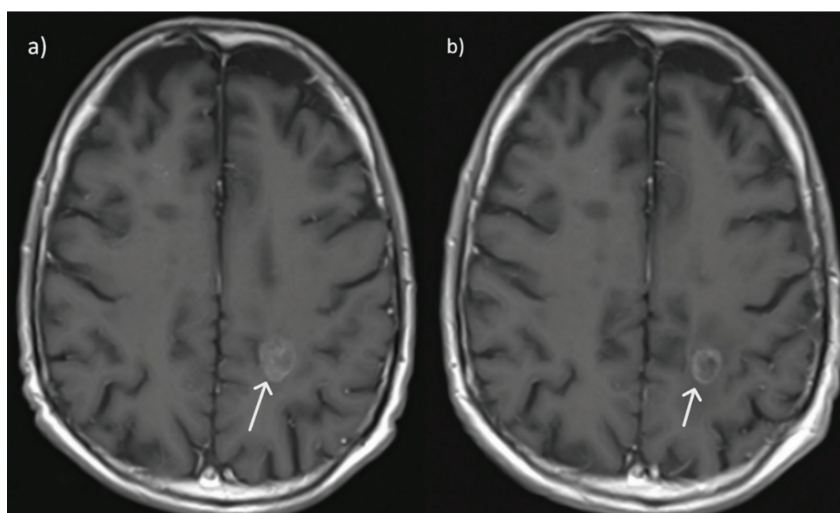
Pre- and post-treatment MRI images of the largest lesion among the patient's multiple metastases prior to the second Gamma Knife surgery in 2019 are shown a) the progressed hemorrhagic metastasis at the supraventricular level in the deep left parietal white matter (measuring 18×14 mm) is observed before the second GKS treatment in 2019. b) After the GKS treatment a regression in size has been observed (measuring 16×12 mm) of the previously mentioned metastasis accompanied by minimal residual signal changes in the peripheral edema region.
